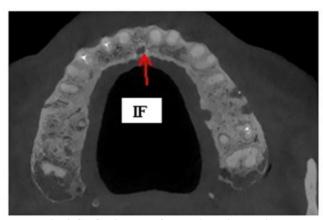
CBCT image of canal in axial section
